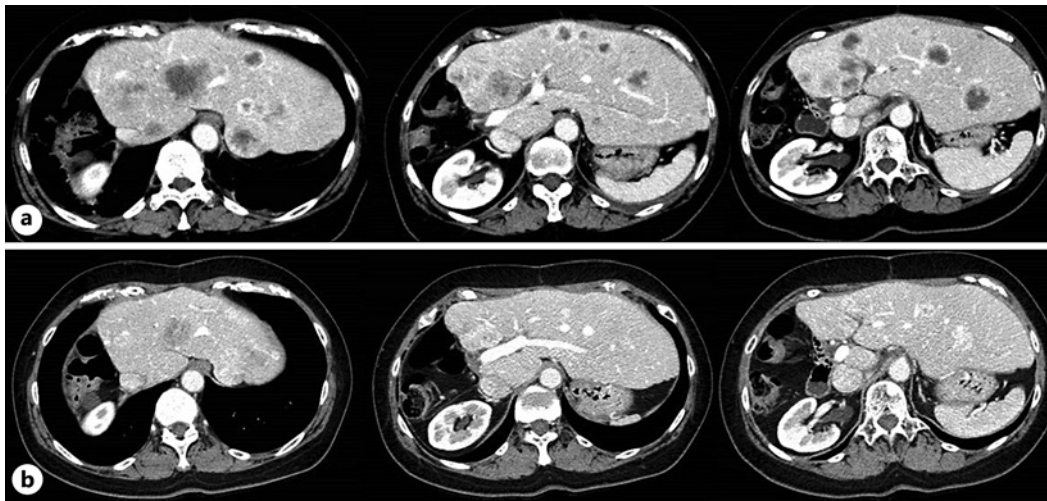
Hepatic masses on abdominal enhanced computed tomography before (a) and 14 months after (b) the initiation of PRRT.
